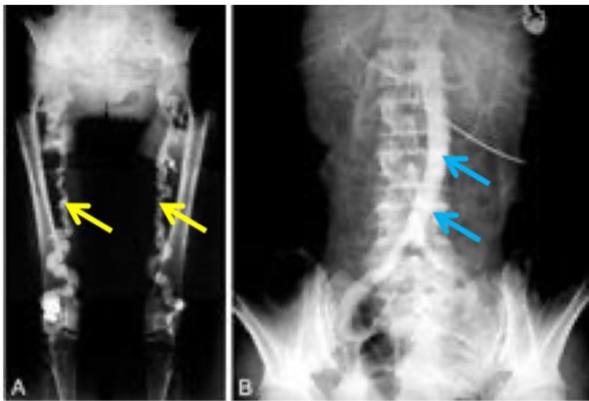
calcifications visible on x-ray and another imaging study
